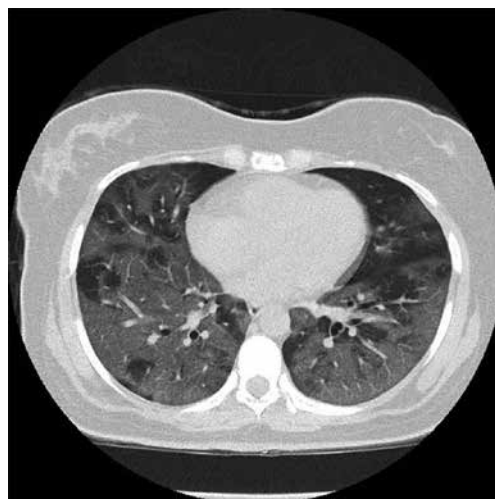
Chest computed tomography (CT) of a 40-year-old female patient diagnosed with COVID-19. Presentation of multifocal bilateral patchy and confluent ground-glass opacities with crazy paving on both lungs. Case courtesy of Dr Bahman Rasuli, Radiopaedia.org, rID: 93230
